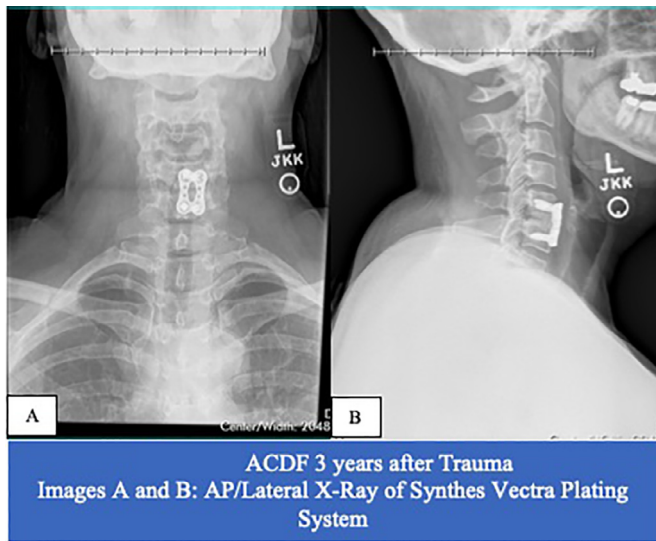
ACDF 3 years after Trauma. Image A and B: AP/Lateral X-Ray of Synthes Vectra Plating System.
